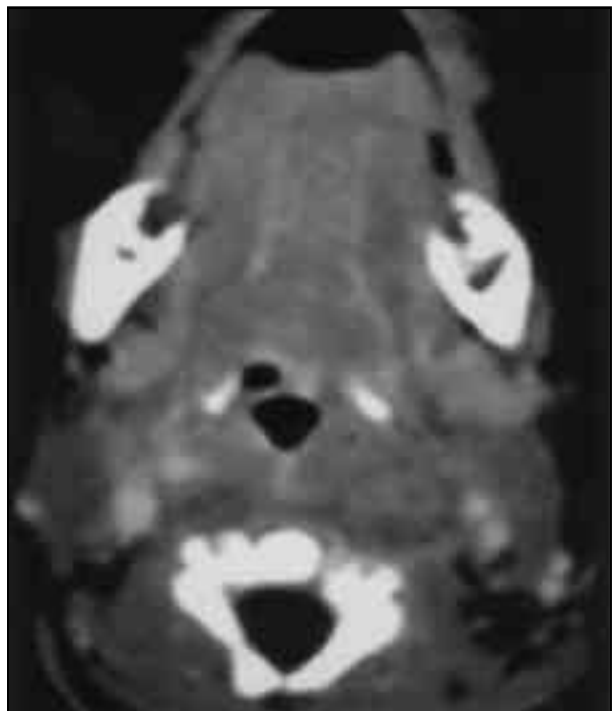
Follow up CT scan after 10 days showing completely resolved abscess with opened up airway
